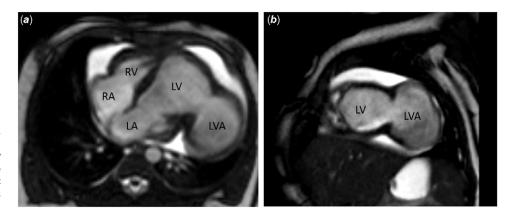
Cardiac MRI: four-chamber (*a*) and short-axis (*b*) projection balanced steady-state-free precession images demonstrating a large LV aneurysm arising from the lateral LV wall with a wide neck and small to moderate pericardial effusion. LA = left atrium; LV = left ventricle, LVA = left ventricular aneurysm; RA = right atrium; RV = right ventricle.
